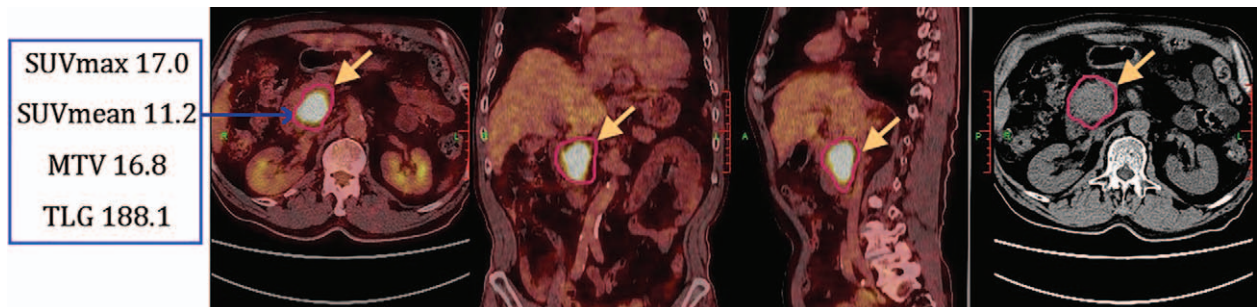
Male, 70 years old, pancreatic head cancer. ¹⁸F-FDG PET/CT fusion images showed a massive shadow in pancreatic head, with increased radioactivity uptake. Four metabolic parameters were all above the cut-off value, and the LDT was 3.9cm. S-1 based chemotherapy was applied first, followed by SBRT treatment. OS of the patient was 16.7 months, and PFS was 9.2 months. LDT=longest diameter of tumor, OS=overall survival, PFS=progression-free survival, SBRT=stereotactic body radiation therapy.
